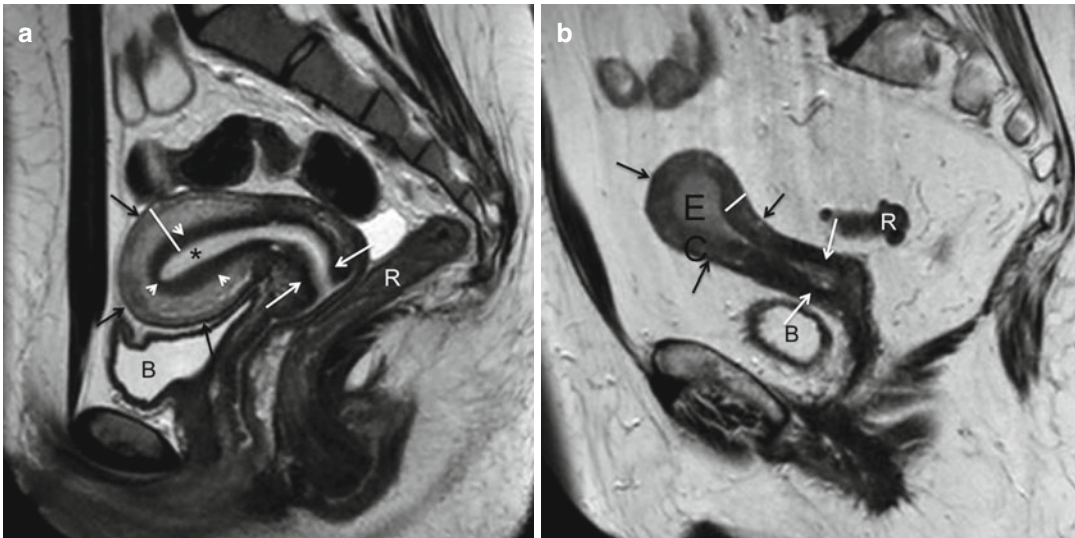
(a, b) Pre- and postmenopausal uterus. Sagittal TSE T2-weighted images (TR/TE 2,400/76 ms) demonstrating uterine anatomy in a premenopausal (a) and in a postmenopausal (b) woman. The hyperintense endometrium (*star*) shows a physiological thickness in case “a”, whereas it appears pathologically thickened (23 mm) in case “b” as a consequence of the presence of an endometrial neoplasm (*EC*). The overall myometrial thickness is highlighted with a white line and is normal in both cases; in premenopausal women (case “a”) the hypointense junctional zone (*white arrowheads*) can be clearly
